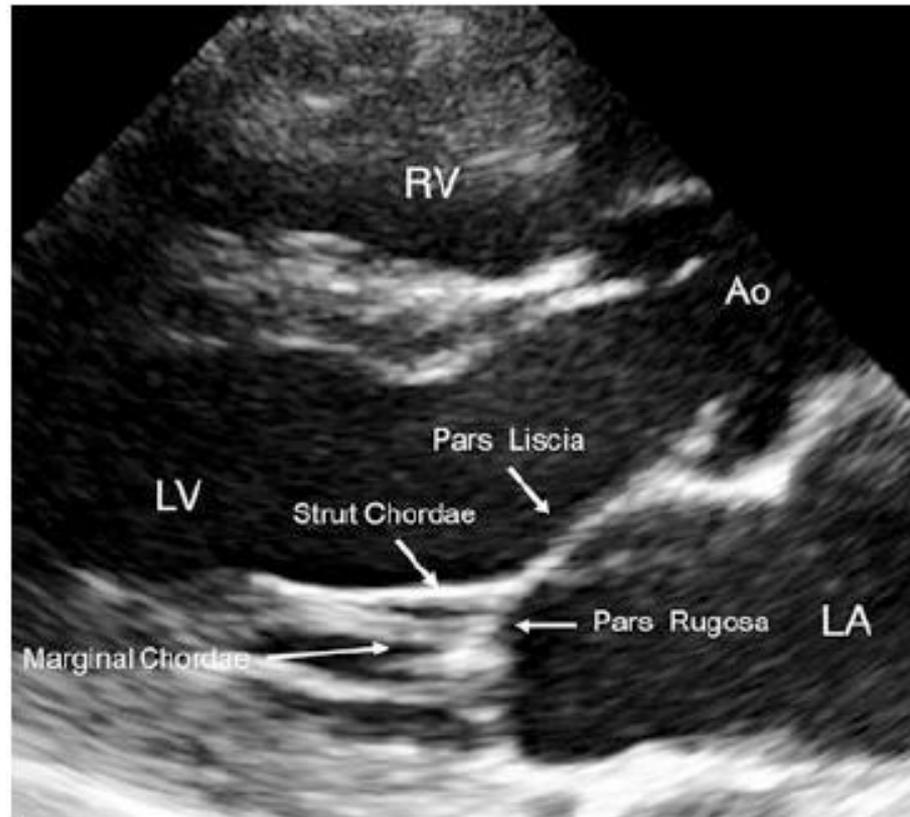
Transthoracic parasternal long-axis echocardiographic images titled medially to visualize the chordae tendineae of the posteromedial papillary muscles. The Pars Liscia and Pars Rugosa, Strut Chordae and Marginal Chordae can be seen. *LA* left atrium, *LV* left ventricle, *RV* right ventricle, *Ao* aorta
